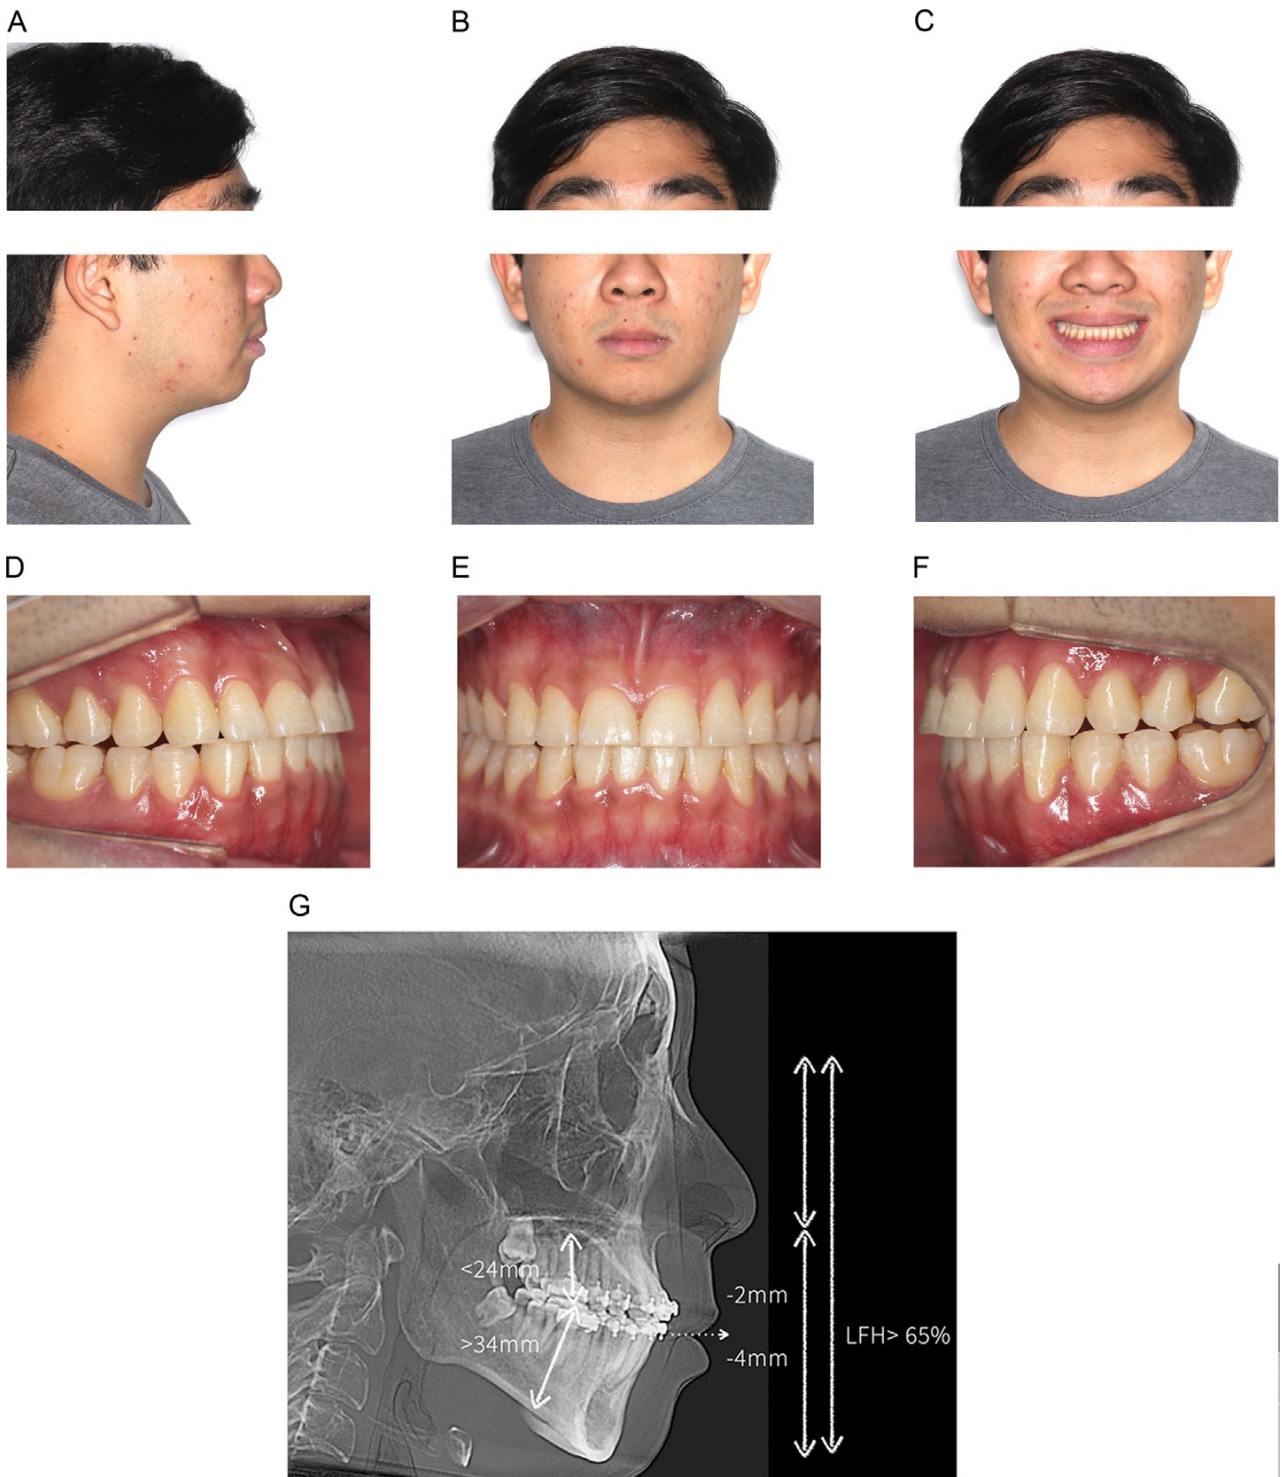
(A–C) Initial extraoral photographs revealing hyperdivergent skeletal pattern, good lip seal, and an inverted smile line. (D–F) Initial intraoral photographs showing right Class I and left Class II occlusion with posterior crossbite and maxillary constriction. (G) Initial cephalometric radiograph with diagnostic factors assessment indicating increased LAFH, reduced maxillary incisor exposure at rest, increased posterior alveolar height, and decreased overbite. (H) Completed checklist for vertical problems, with diagnostic findings and proposed treatments: molar intrusion, maxillary and mandibular incisor extrusion. (I–K) Final extraoral photographs showing improved smile line. (L–N) Final intraoral photographs demonstrating successful open bite closure and corrected occlusal relationships. (O) Final cephalometric radiograph with evidence of maxillary molar and premolar intrusion, with root displacement into the maxillary sinus region. (P) Models superimpositions showing maxillary incisor extrusion, and secondary mandibular incisor extrusion resulting from counterclockwise mandibular rotation.
